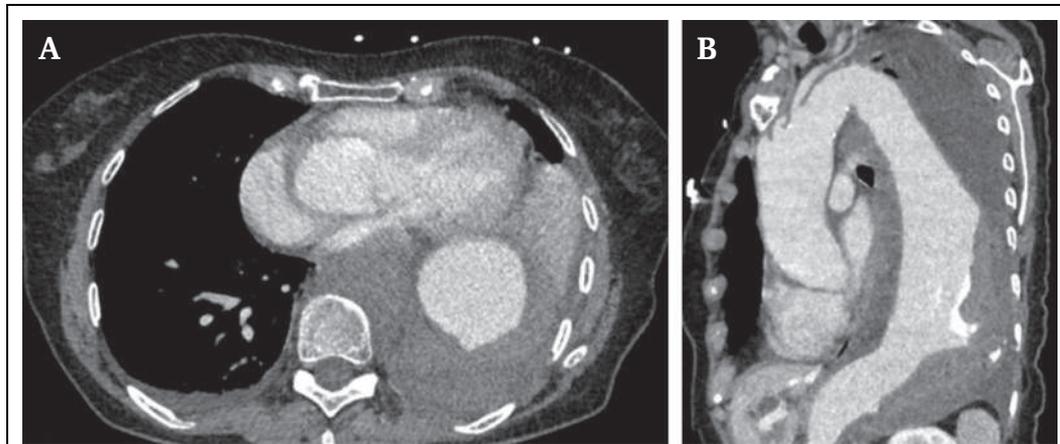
Ruptured thoracic aortic aneurysm with bilateral haemothoraces. (A) Axial computed tomography angiography (CTA) demonstrating rupture of the descending thoracic aortic aneurysm with a large, left-sided haemothorax. (B) Sagittal multiplanar reconstruction showing the rupture site, extent of the aneurysm, and associated haemorrhage (artist and copyright Carlota F. Prendes, Uppsala, Sweden).
